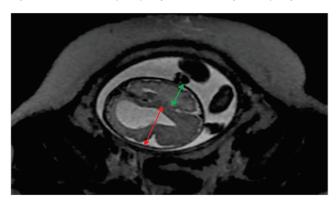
MRI shows colpocephaly with hemimegalencephaly.
